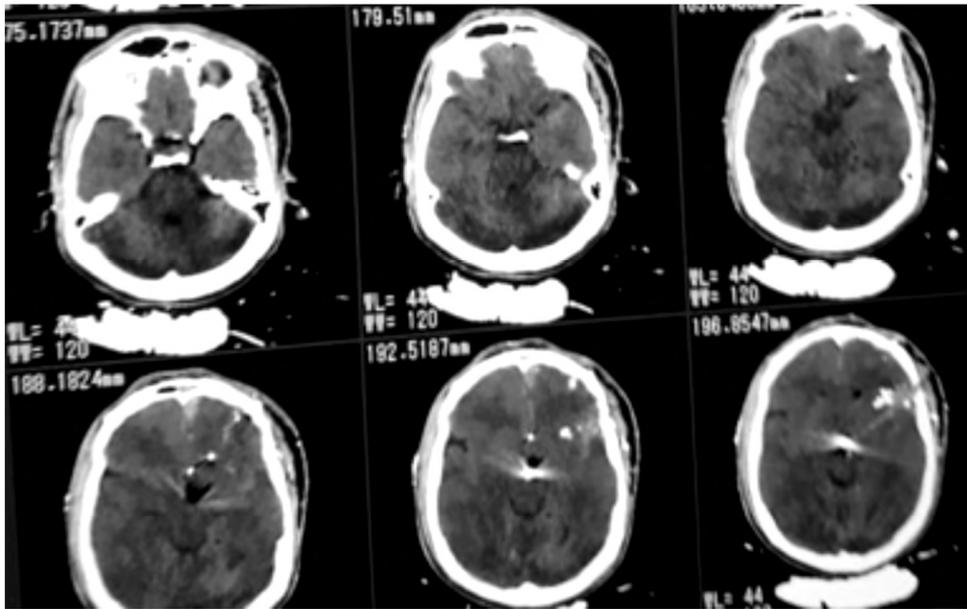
CT Brain showing the shot and bone fragment reaching all zones.
